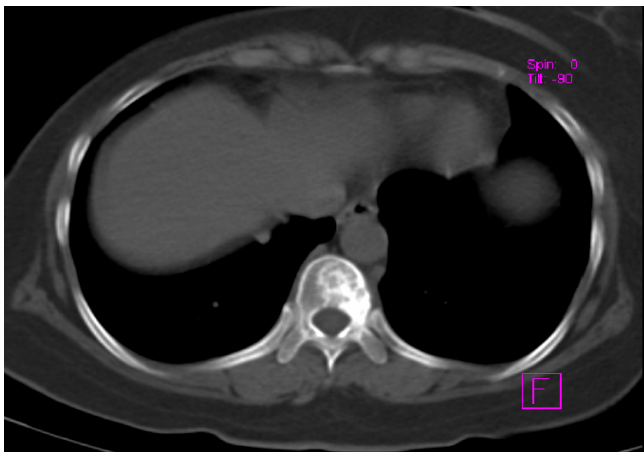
CT scan bone window shows predominantly sclerotic lesion in T10 on left side
